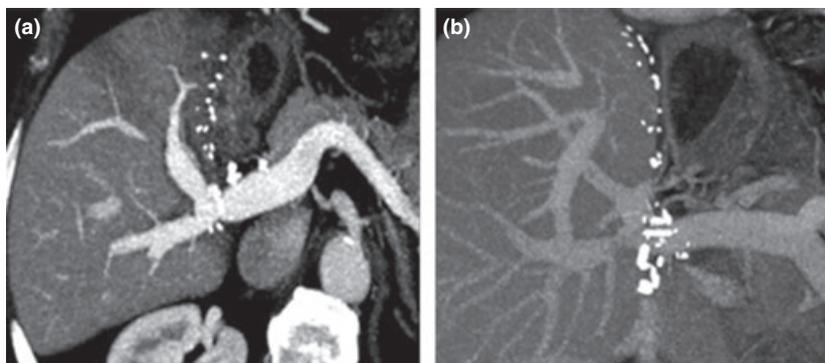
Postoperative computed tomography images of quiltplasty technique performed for type 4 portal vein anomaly. (a) Quilt-plasty by using double iliac vein grafts. (b) Quilt-plasty by using a combination of saphenous and iliac vein grafts.
